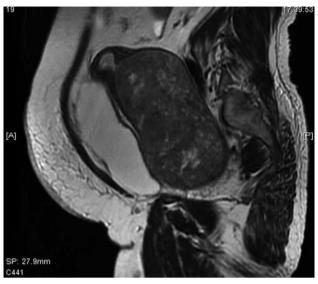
Sagittal T2 weighted magnetic resonance image of the pelvic region. A large cervical myoma is seen, elevating the uterus.
